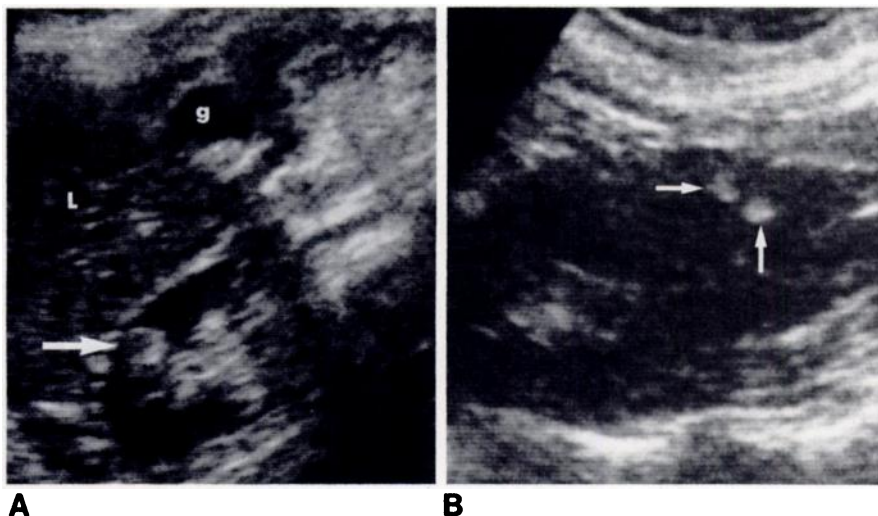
51-year-old woman with symptoms of gallbladder disease. Transverse (A) and sagittal (B) sonograms of right kidney. Three small echogenic intraparenchymal renal lesions (arrows). L = liver; g = gallbladder with gallstones.
